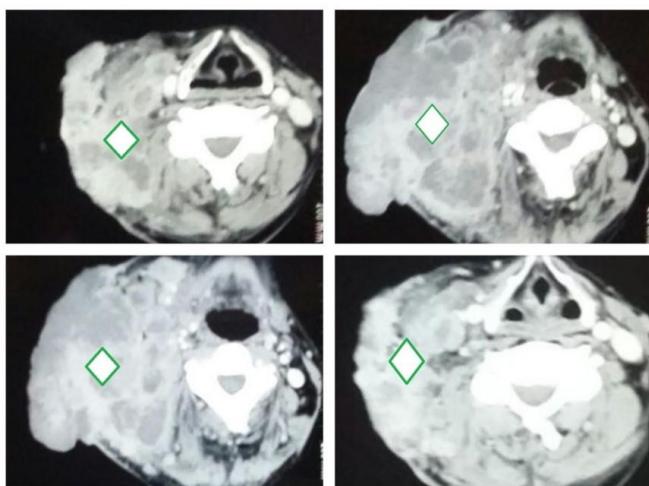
48-year-old patient with a history of HIV. FNA: Sarcomatoid type lesion. CT: heterogeneous lesion, very bulky, no contrast-enhanced, and with hypodense center compatible with central necrosis
